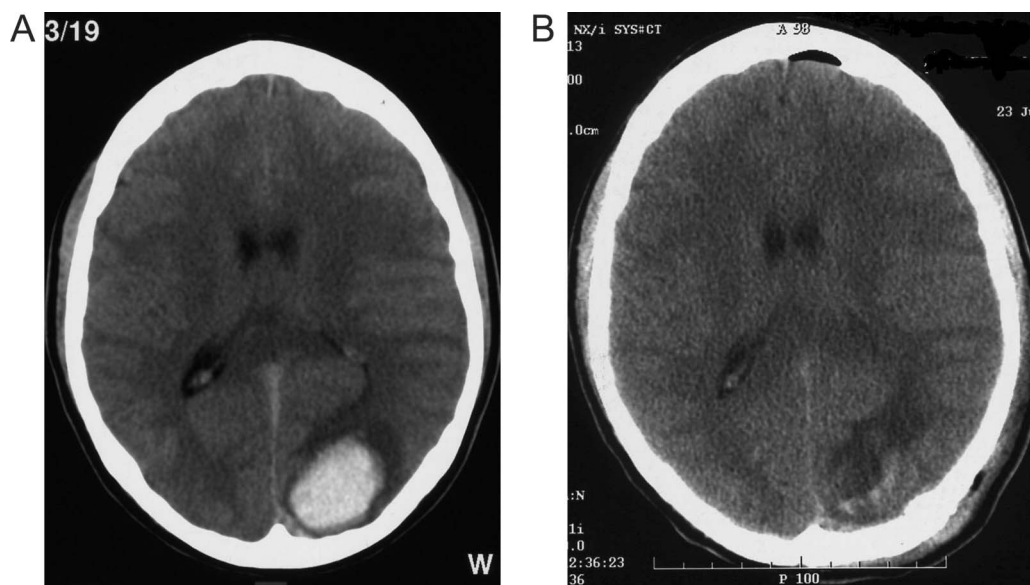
Preoperative CT scan showing left occipital haemorrhage (28 cm³) (Panel A); Postoperative CT scan showing the operative cavity (Panel B).
